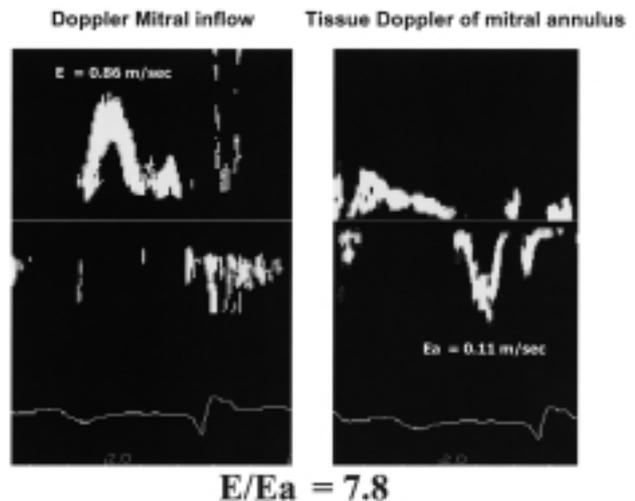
Standard Doppler inflow (left panel) and tissue Doppler of the left ventricular mitral annulus (right panel). The E/Ea ratio is 7.8.
